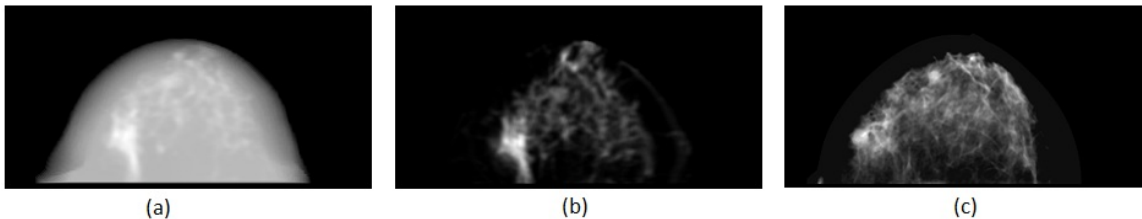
Transformed intensity images: (a) Projected pseudo-CT; (b) Fibroglandular thickness computed from MRI scan; (c) Fibroglandular thickness computed from mammogram.
